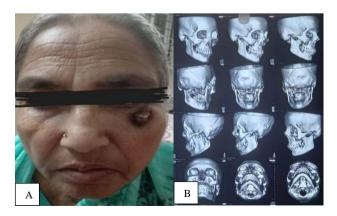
(A and B): Pre operative picture showing left malar swelling and CT facial skeleton (3D).
